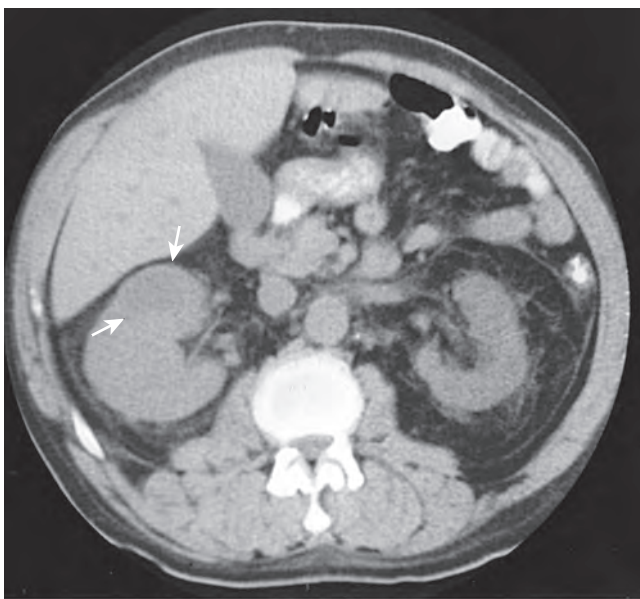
Acute renal abscess. Nonenhanced computed tomography scan through the mid pole of the right kidney demonstrates right renal enlargement and an area of decreased attenuation (arrows). After antimicrobial therapy, a follow-up scan showed complete regression of these findings.
